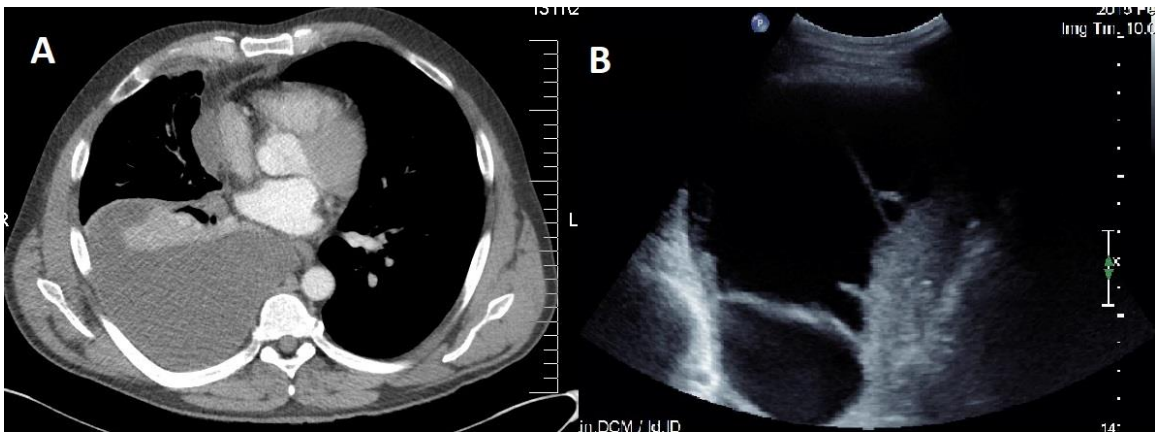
A) Coronal CT image shows right pleural effusion without any evidence of septations B) The corresponding ultrasound image reveals the presence of heterogeneous septations.
